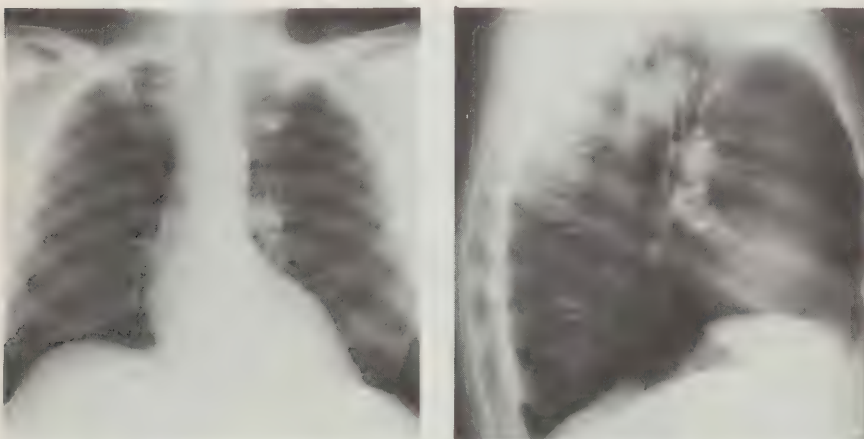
Chest roentgenogram in P-A and left lateral projection 48 hours after that shown in Fig. 2. Note clearing of pleuropulmonary abnormality and normal size of cardiac silhouette.
